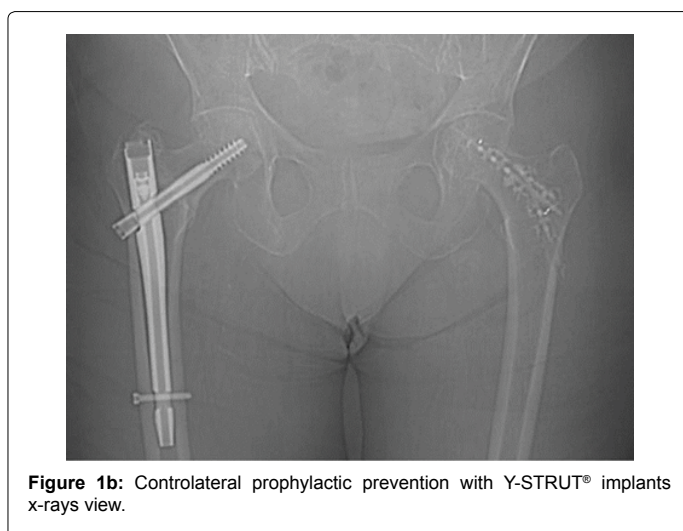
Contralateral prophylactic prevention with Y-STRUT[®] implants x-rays view.
